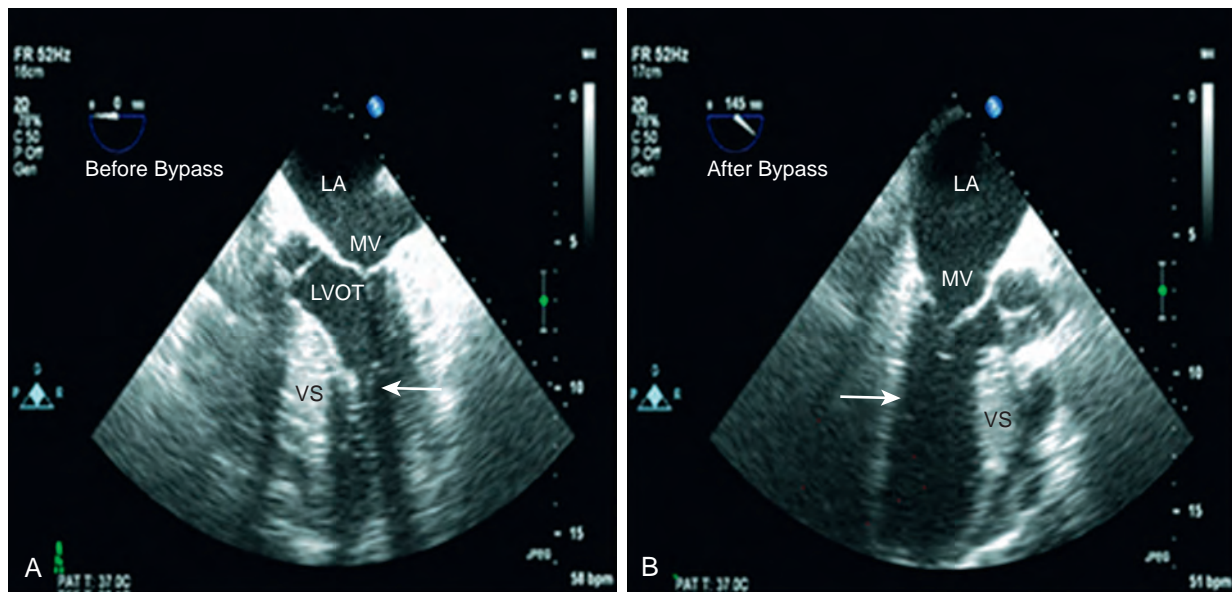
Intraoperative transesophageal echocardiographic images of a patient with midventricular hypertrophy before and after surgical resection. (A) Midesophageal five-chamber view before resection shows the hypertrophied midventricular septum (arrow). (B) Midesophageal long-axis view after resection shows the now-opened left ventricular cavity (arrow) after a transapical approach. LA, Left atrium; LVOT, left ventricular outflow tract; MV, mitral valve; VS, interventricular septum. (Reproduced with permission from Said SM, Schaff HV, Abel MD, Dearani JA. Transapical approach for apical myectomy and relief of midventricular obstruction in hypertrophic cardiomyopathy. *J Card Surg.* 2012;27:444.)
